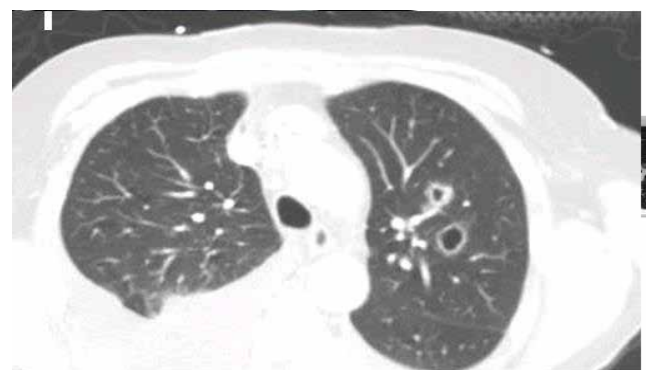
Thoracic CT-scan: disseminated pulmonary nodules.
